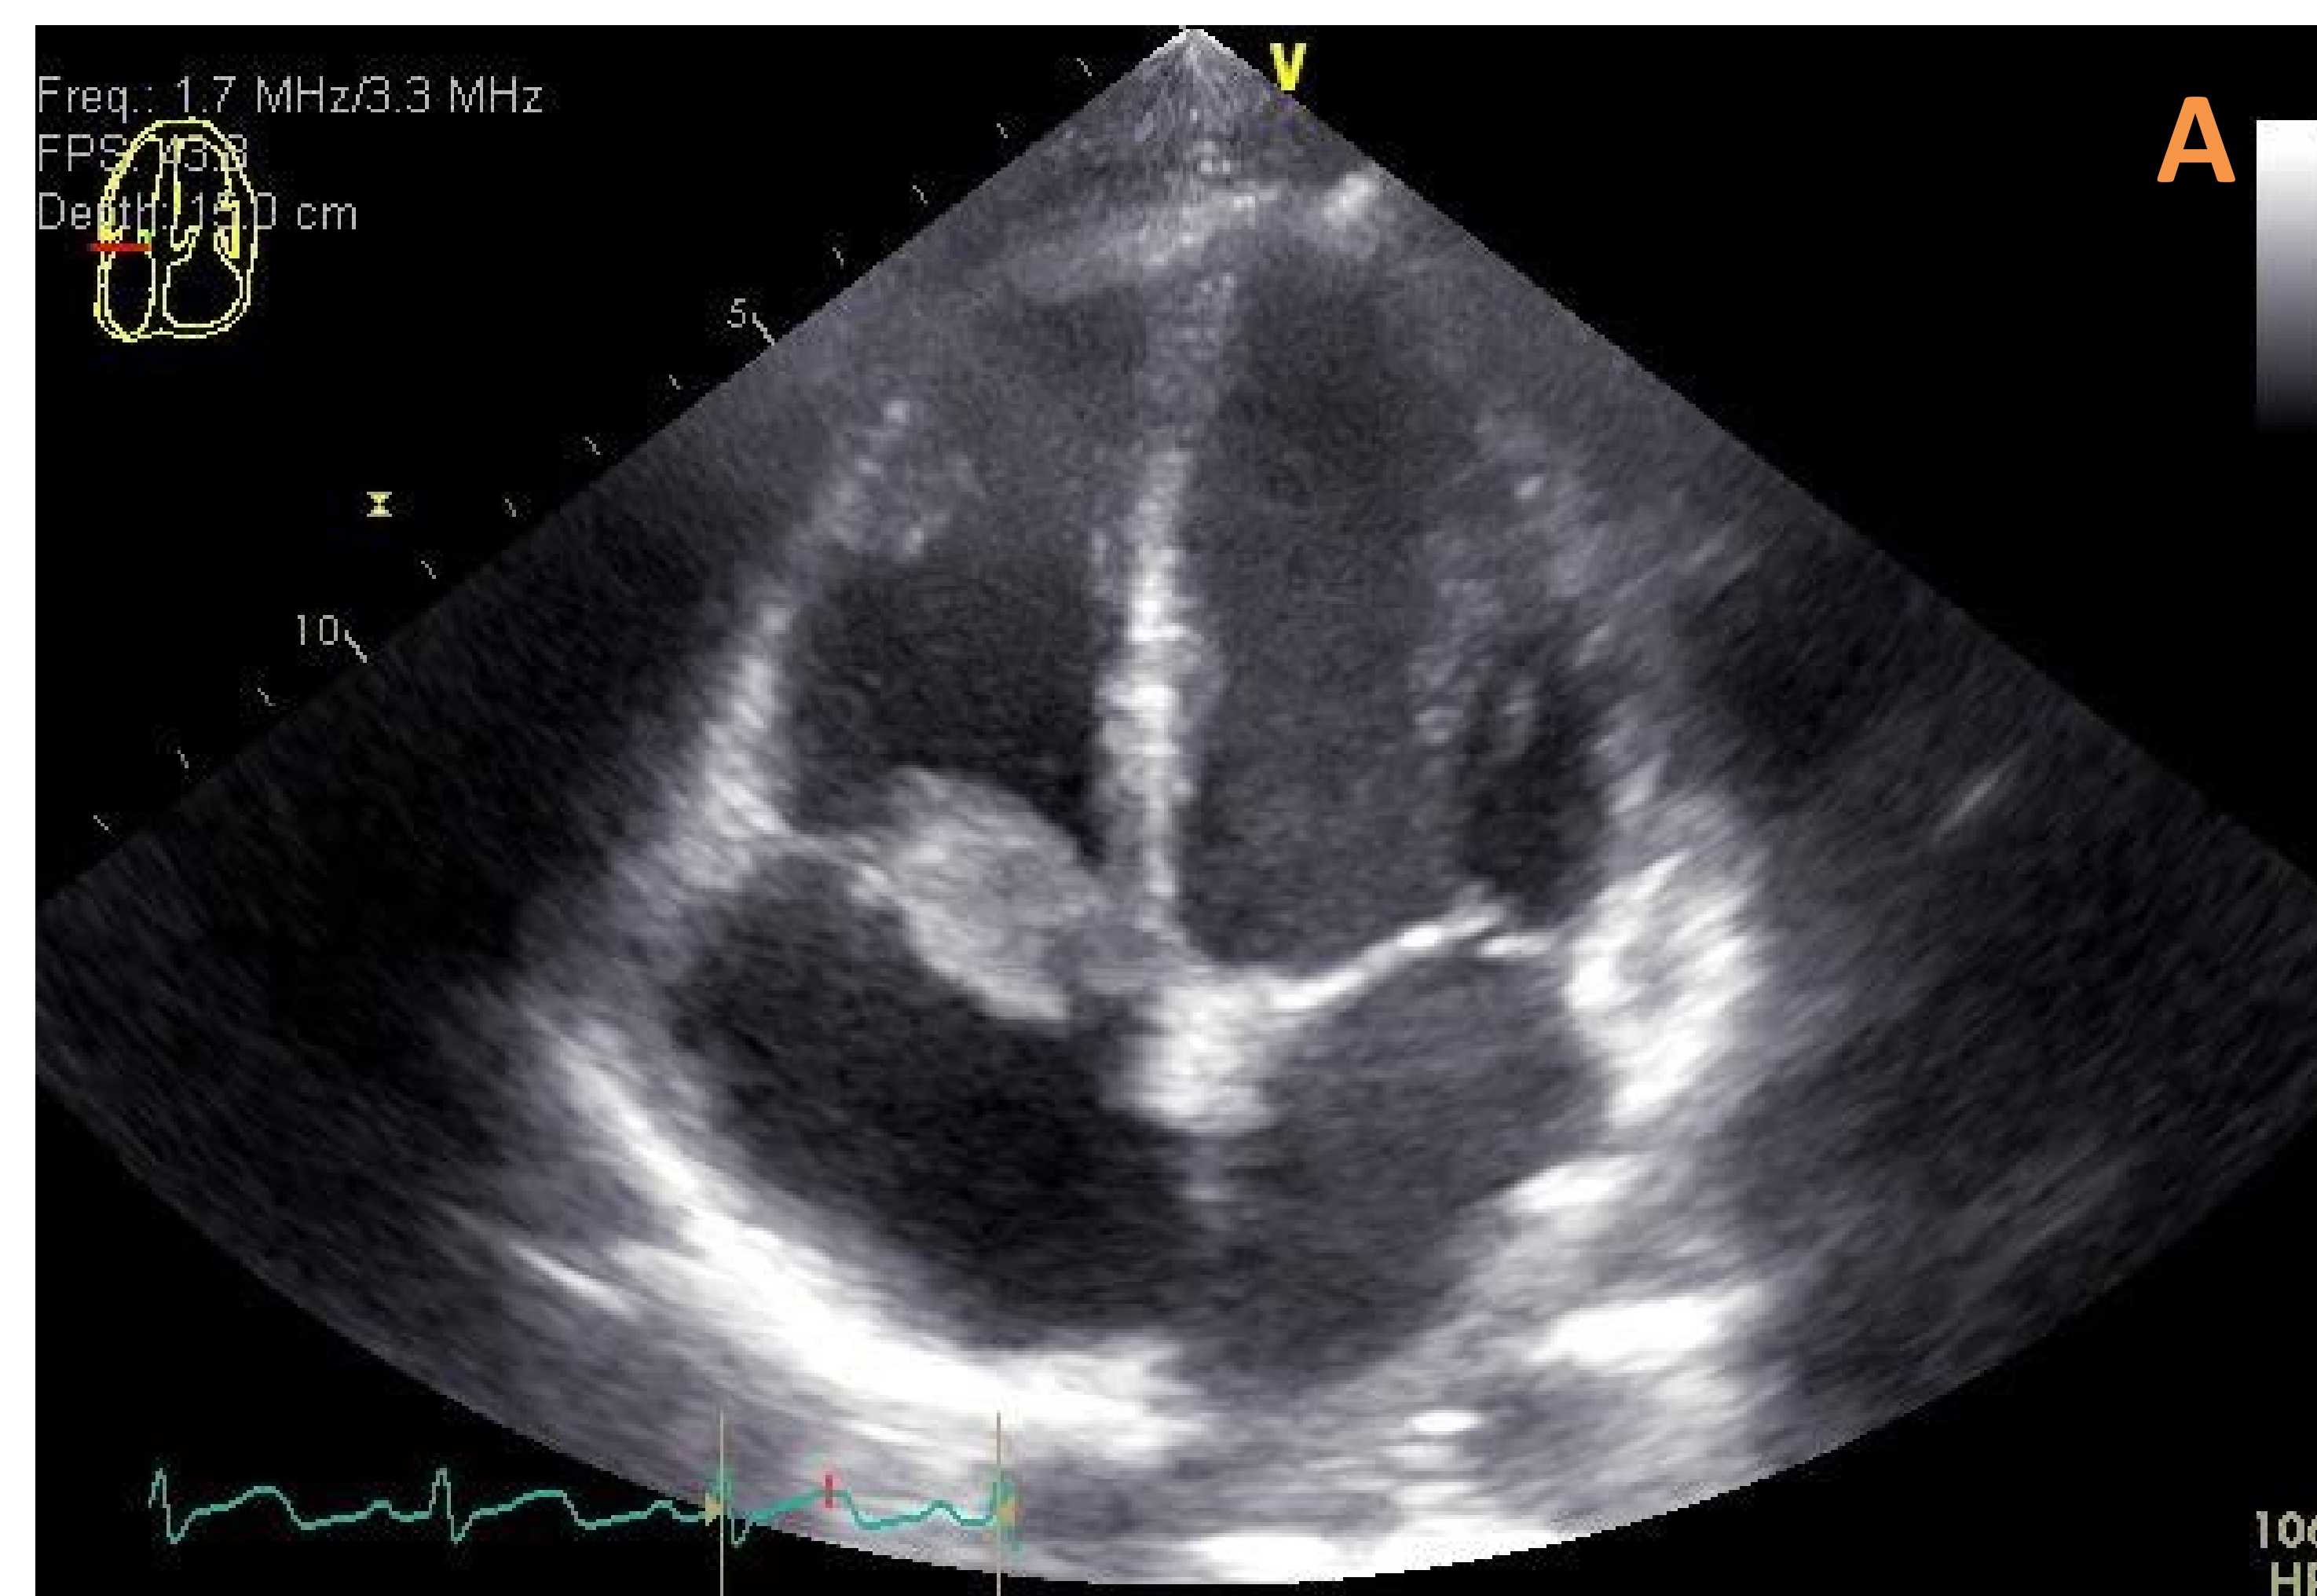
TTE apical 4 chamber view demonstrated a large vegetation on the anterior and septal leaflets of the tricuspid valve and the subvalvular apparatus with severe tricuspid regurgitation with the largest portion of the vegetation measures 3.0 x 1.1 cm (A). TEE mid esophagus view redemonstrating large vegetation on the anterior and septal leaflets (B). Vegetations extracted from surgical excision (C). Post operative TEE demonstrating extracellular matrix cylinder reconstruction (D).
